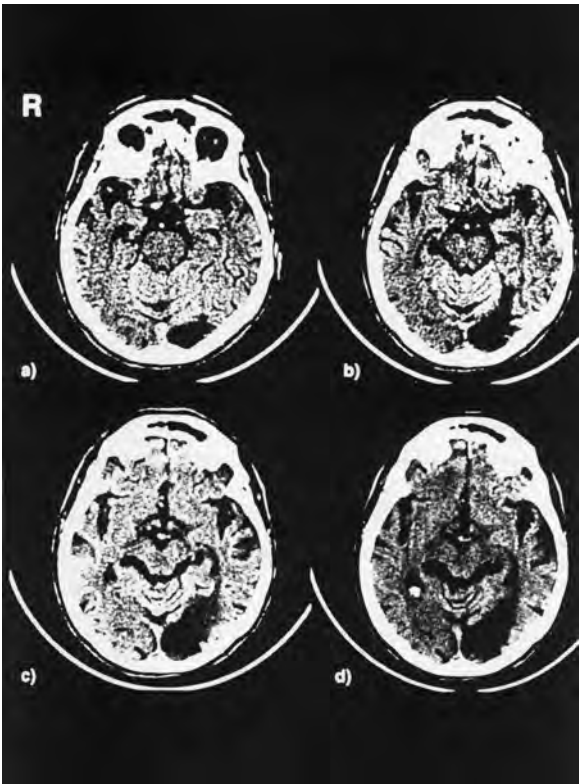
CT scan showing an older infarction of the lower left occipital pole and an acute infarction of the lower right occipital pole, which is not clearly visible at this early stage. Although the diagnosis of an
